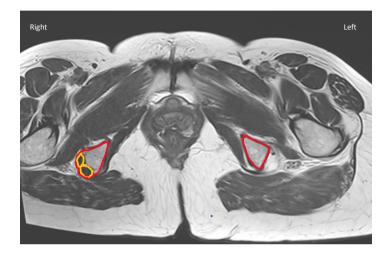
T2-weighted axial image. Right ischial tuberosity showing "two yellow scoops of ice cream" at the bone. The conjoint tendon is shown medially, and the semimembranosus tendon is shown laterally. The left ischial tuberosity showing "no scoop of ice cream and only cone (bone) left", both conjoint and semimembranosus tendons are avulsed.
